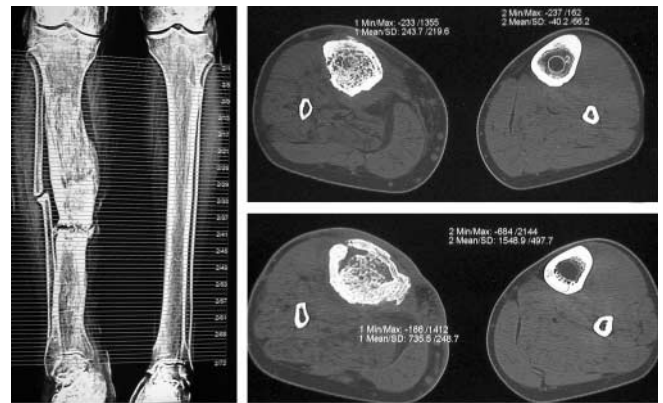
Proximal regeneration of the tibia in a 31-year-old man 628 days after the completion of transport. The comparative CT scans clearly indicate the spongiosis of the regenerated medullary canal
